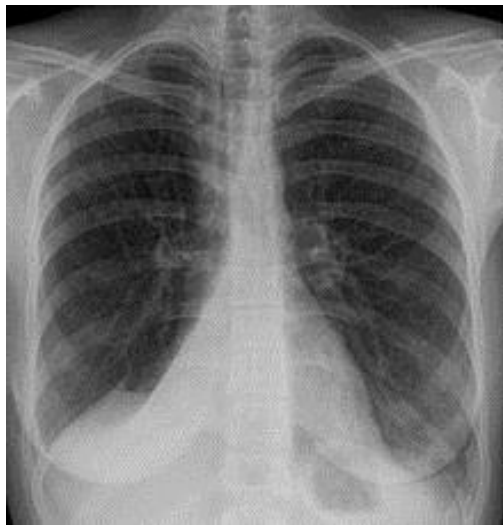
Bilateral lower lobe atelectasis chest x-ray (*McAlister et al., 2005*).
